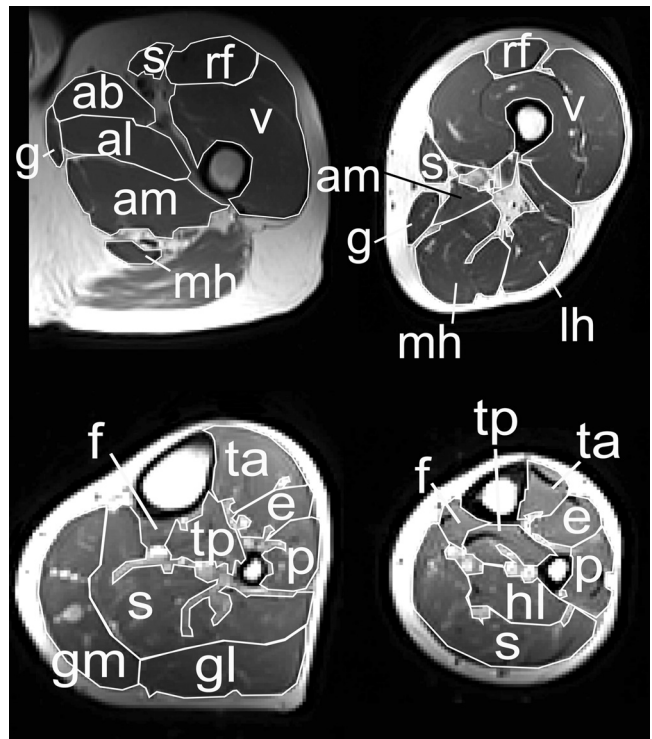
Muscle measurements on magnetic resonance images. Images are from the proximal thigh (top, left), distal thigh (top, right), proximal lower leg (bottom, left), and distal lower leg (bottom, right). Thigh: ab, adductor brevis; al, adductor longus; am, adductor magnus; g, gracilis; s, sartorius; rf, rectus femoris; v, vasti; mh, medial hamstrings (semimembranosus and semitendinosus); lh, lateral hamstrings (biceps femoris long and short heads). Pectineus is not shown. Lower leg: f, flexor digitorum longus; s, soleus; gm, medial gastrocnemius; gl, lateral gastrocnemius; ta, tibialis anterior; tp, tibialis posterior; e, extensor digitorum longus; p, peroneals; hl, flexor hallucis longus.
